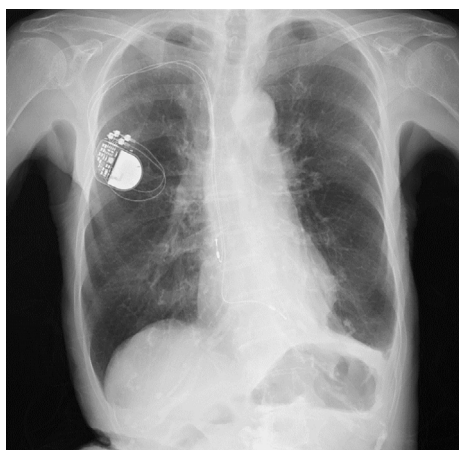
Chest X-ray obtained one week after reimplantation.
